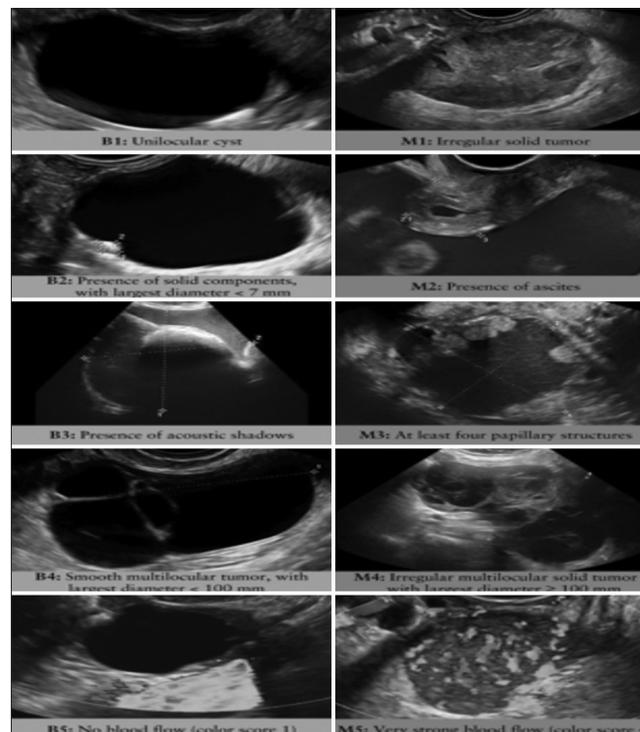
Shows the IOTA ultrasound rules
